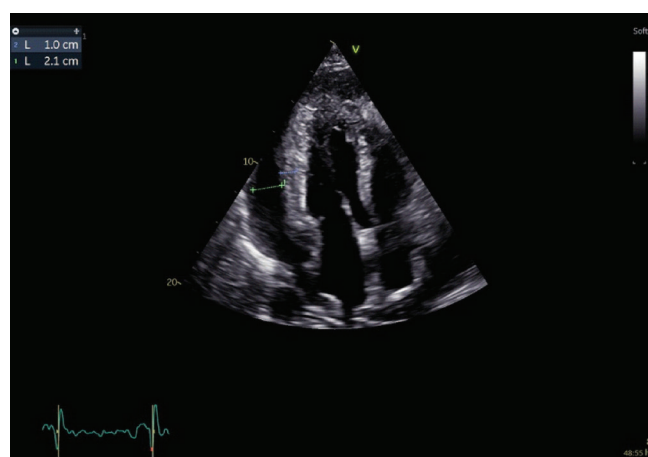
Transthoracic echocardiography; three chamber apical view showing thickening of visceral pericardium (10 mm) and pericardial effusion of 21 mm.
